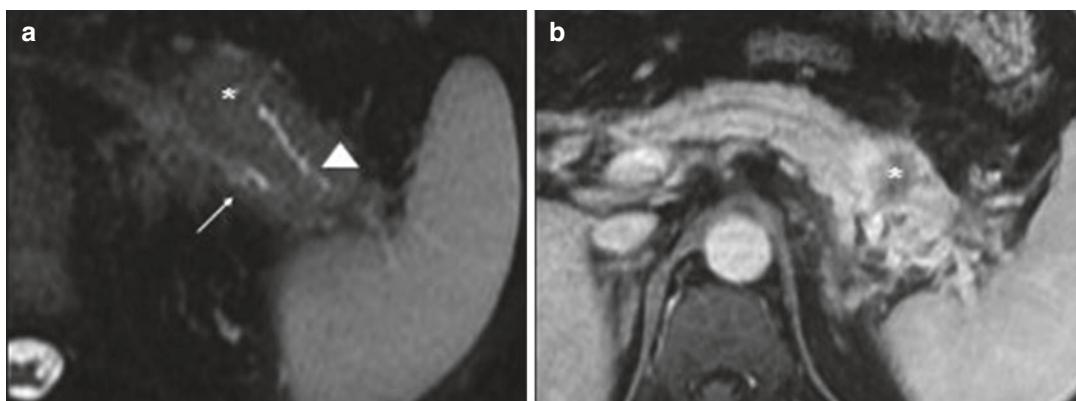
Acute interstitial edematous pancreatitis of the tail caused by an obstructing mass in a 55-year-old man presenting with left upper quadrant pain. Endoscopic biopsy confirmed pancreatic adenocarcinoma. Axial T2-weighted (a) and post-contrast T1-weighted (b) MR images show abrupt cutoff of a dilated main pancreatic
